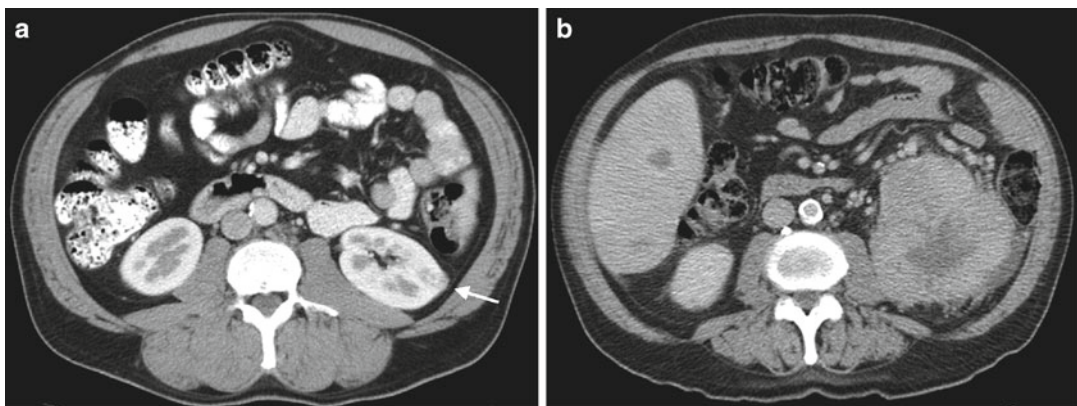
Computed tomographic images of an SRM that has 20 % or greater likelihood of being benign, typically slow growth rate, and low metastatic potential (a) and a locally
